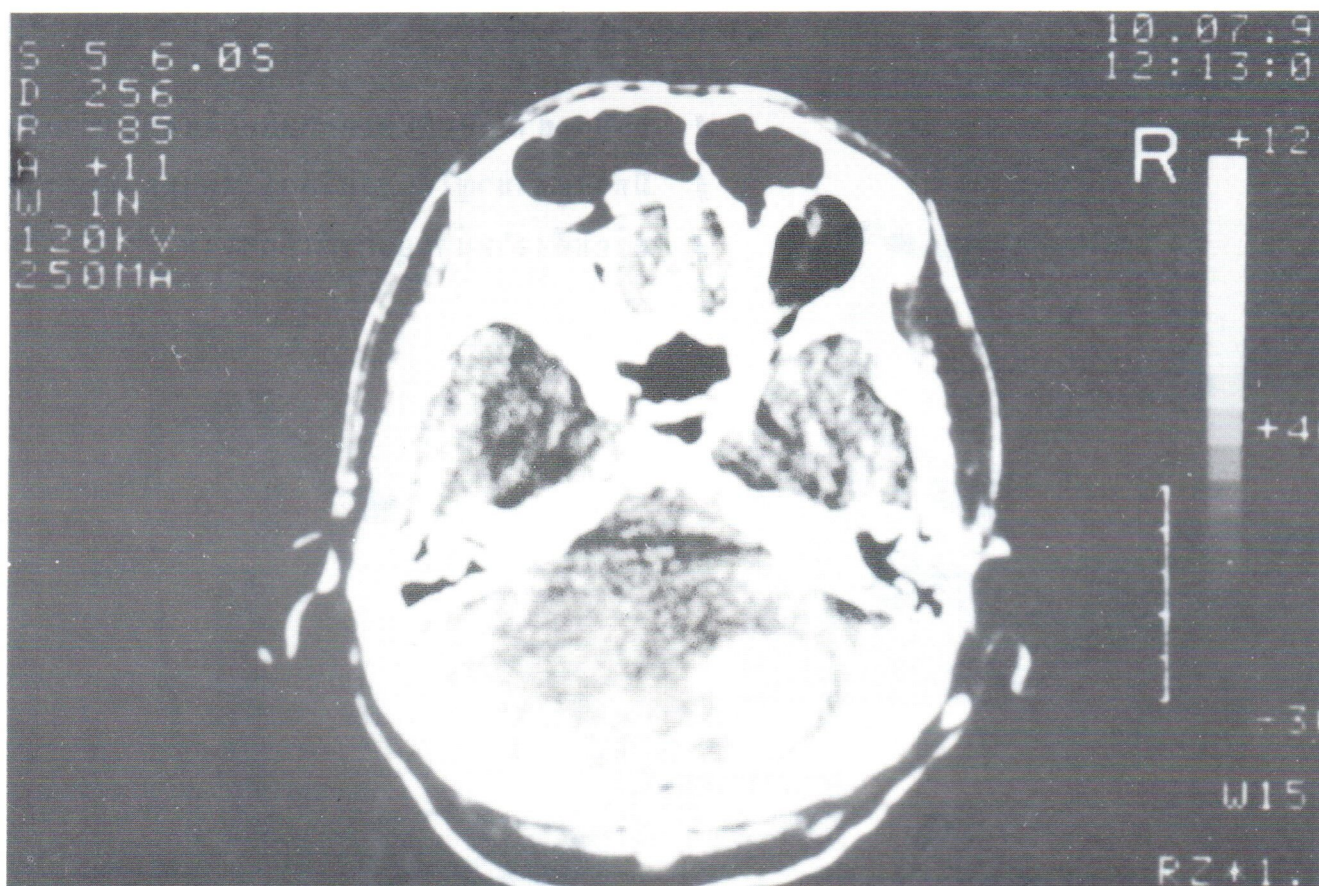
Contrast enhanced CT of the brain shows a focal enhancing nodule in the right cerebellar hemisphere representing metastatic angiosarcoma.
